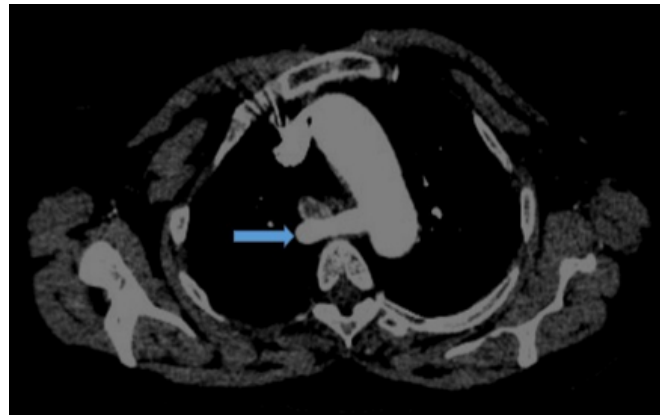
Thorax CT showing the aberrant right subclavian artery (arrow).
